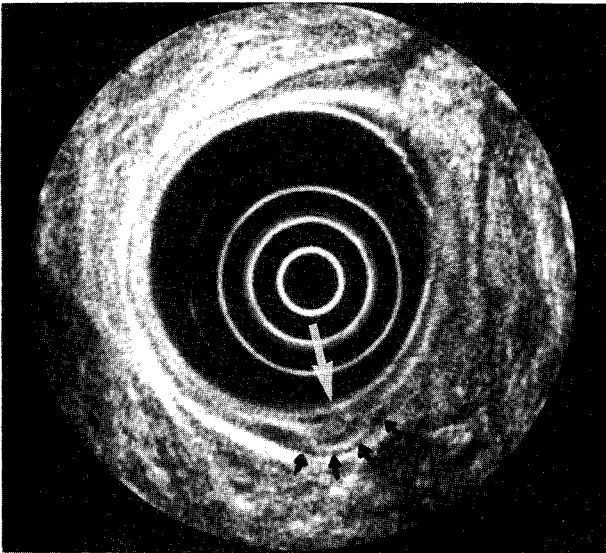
Endoscopic ultrasound image of a hypoechoic tumor (large arrow) limited to the mucosa and submucosa, leaving the muscularis propria (small arrows) intact. There are no lymph nodes. These data are consistent with a T1sm cancer in a patient with Barrett's esophagus.
